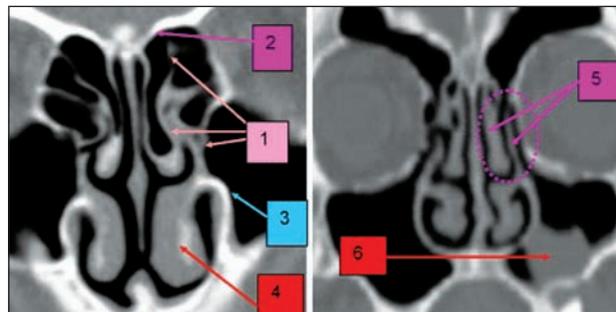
Paranasal sinuses CT scan, bone window, coronal slices: 1. left uncinatoprocess multiple insertion into the middle turbinate, skull base, external wall of the nasal fossa; 2. skull base; 3. maxillary sinus; 4. hypertrophy of the left inferior turbinate; 5. left uncinatoprocess insertion into the lamina papyracea, as part of the double turbinate (duplicate); 6. left maxillary sinus inflammatory process
